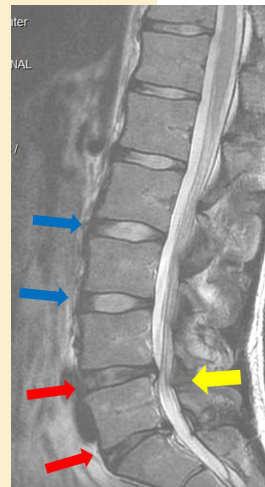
Sagittal (side view) MRI scan of Aaron's low back showing normal discs (blue arrows) at the top and degenerated discs (red arrows) at the bottom. The large yellow arrow shows where the nerves in his spine are being pinched.
